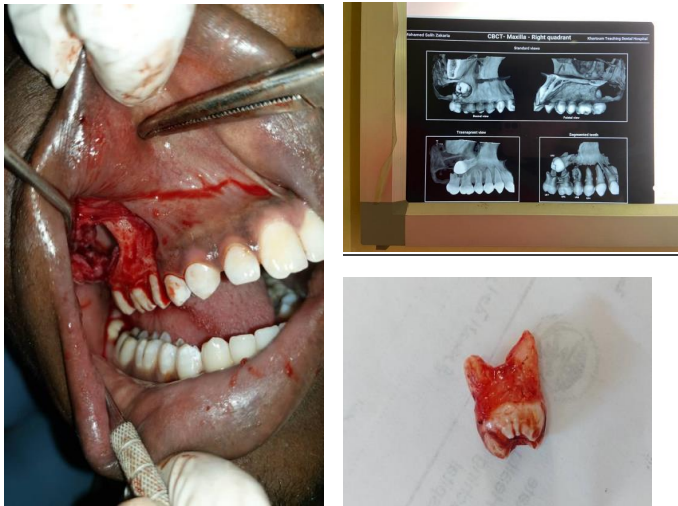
Showing intra-operative photo, CBCT and impacted wisdom tooth.
